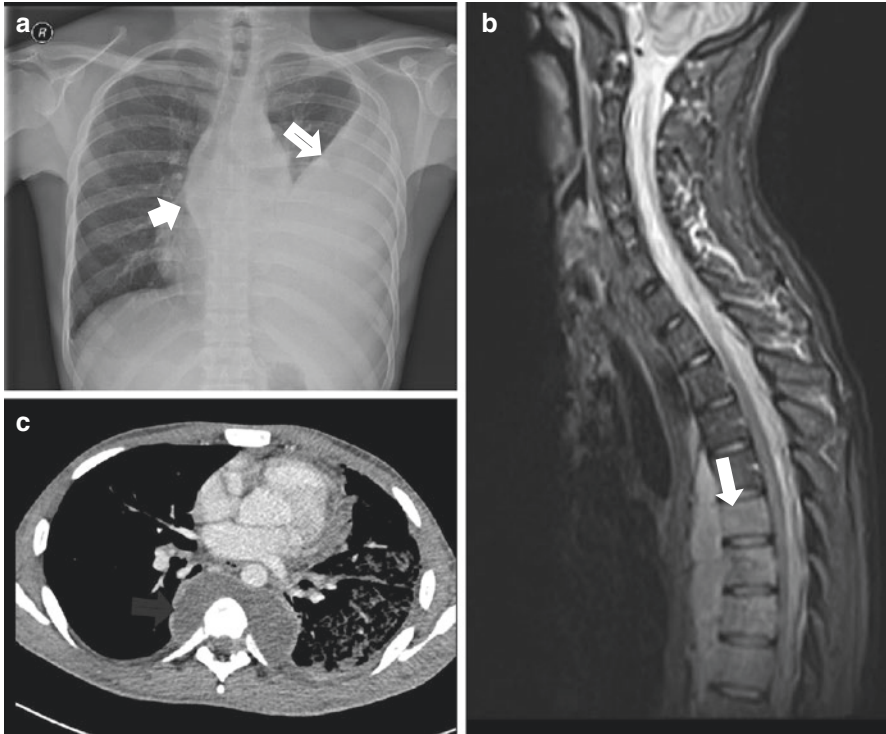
Spondylitis. Chest X-ray (a) demonstrates a large left pleural effusion (meniscus indicated by open arrow) and a fusiform paravertebral mass (closed arrow). This is confirmed to be a large paravertebral abscess on CT (open arrow, b). Sagittal STIR MRI (c) demonstrates oedema within the lower thoracic vertebrae (open arrow) and subligamentous spread of infection with preservation of the intervertebral discs
